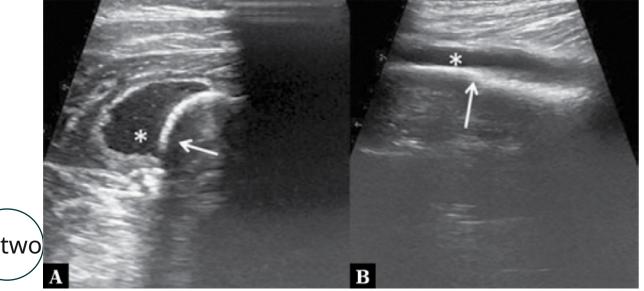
Collection located in the deep subcutaneous tissue, in contact with the bone surface. Axial (A) and sagittal (B) showing deep collection (asterisk), located in the distal metaphyseal third of the femur (white arrow). Source:Paliwal AK, Sahdev R, Deshwal A, Ram B. Role of ultrasound in the diagnosis of pediatric acute osteomyelitis. J Ultrason. 2021;21(84):34-40. doi: 10.15557/JoU.2021.0005. Epub 2021 Mar 8. PMID: 33791114; PMCID: PMC8008204.
